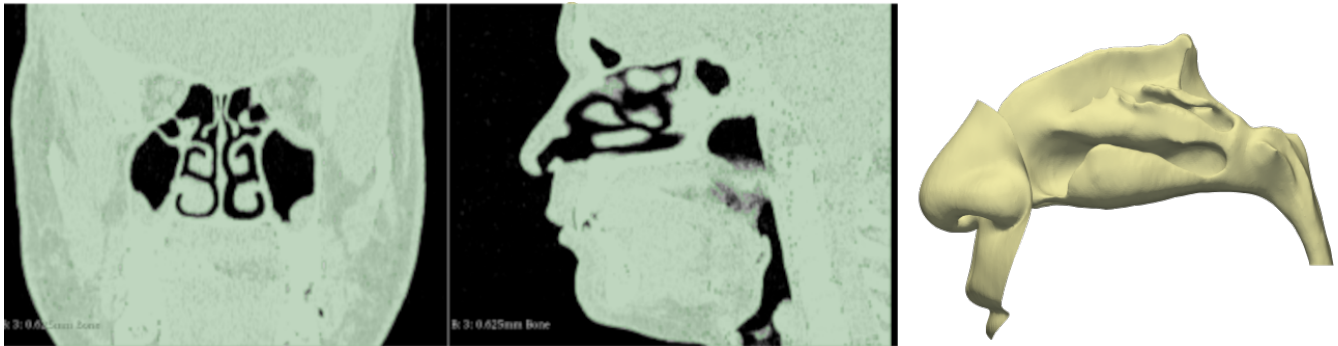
Nasal anatomy: from the CT scan (left) to an STL after removal of the sinuses (right).
